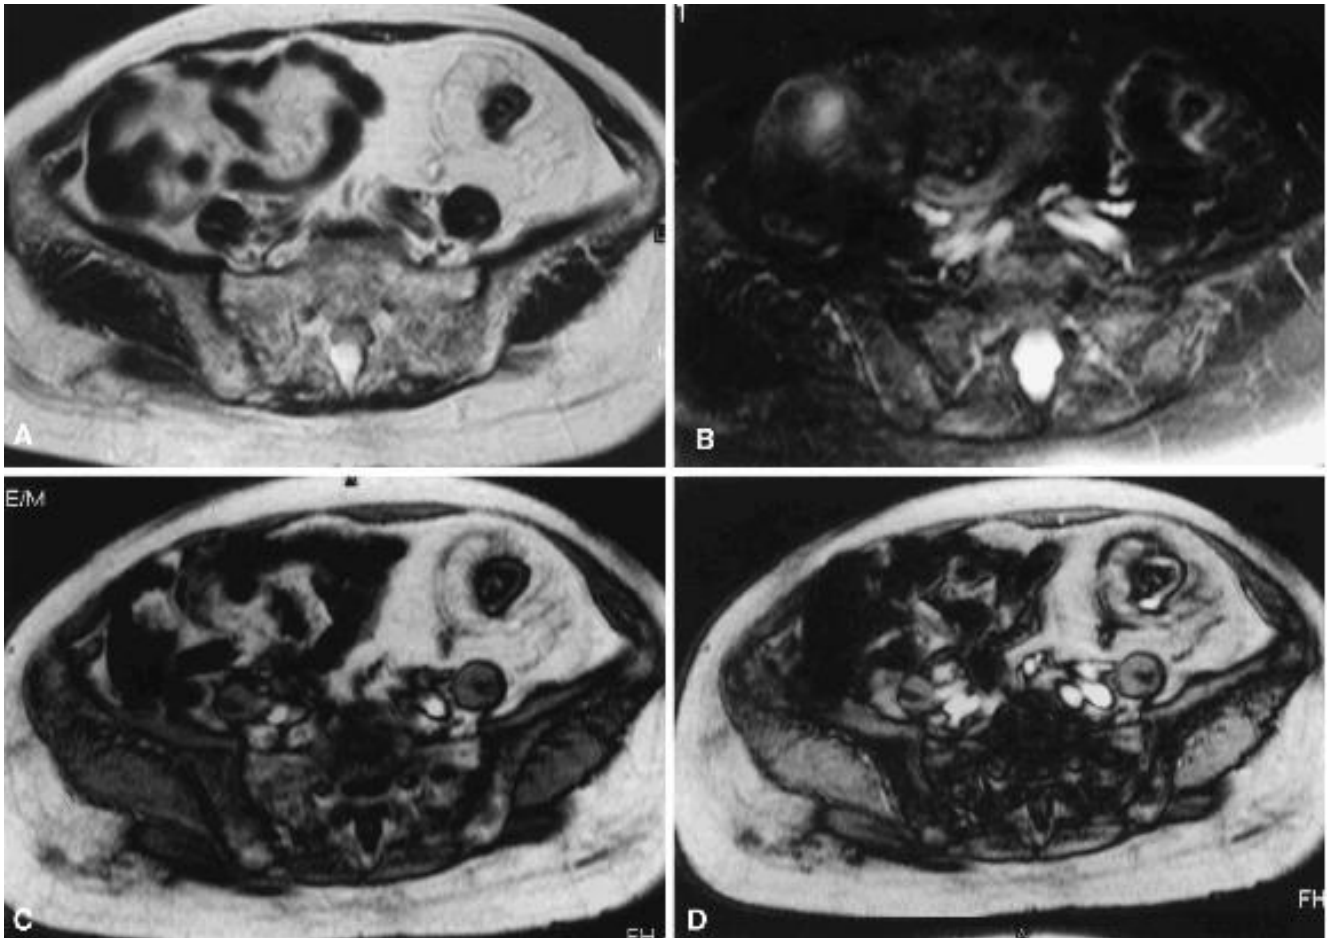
An 81-year-old female patient, with a long history of Crohn disease, treated with corticosteroids. A The axial T2-weighted TSE image shows wall thickening at the level of the sigmoid colon, with marked fibrofatty proliferation displacing the adjacent ileal loops. B Axial fat-suppressed T2-weighted TSE image demonstrates lack of wall signal at the level of the sigmoid wall, except for a focal area at the mesenteric side; no significant signal is evident in the fibrofatty tissue. C Axial breath-hold T1-weighted TFE image shows wall thickening and fibrofatty proliferation. D Axial breath-hold T1-weighted TFE image obtained after gadolinium injection demonstrates low or absent enhancement, except for a focal area in the sigmoid wall. Colonoscopy showed normal mucosa at the level of the sigmoid colon.
